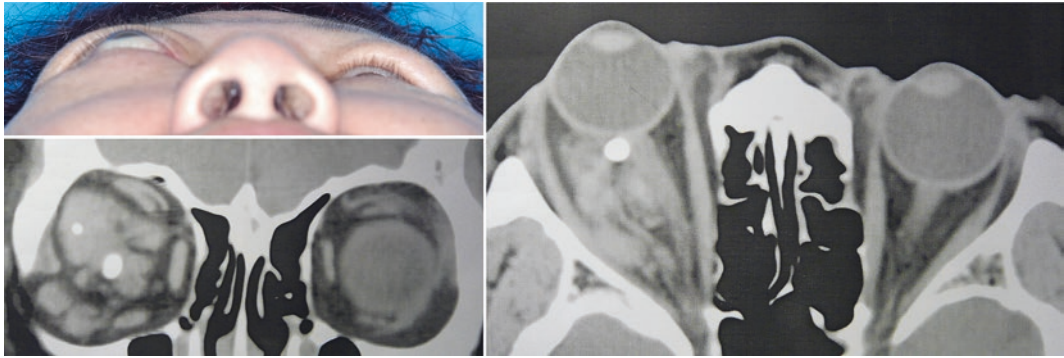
Non-distensible venous malformation causing severe right-sided axial proptosis. CT scan showing intraconal, venous malformation. Presence of phleboliths reflects previous episode(s) of thrombosis. They appear as high(bone)-density, small round lesions on CT scans
